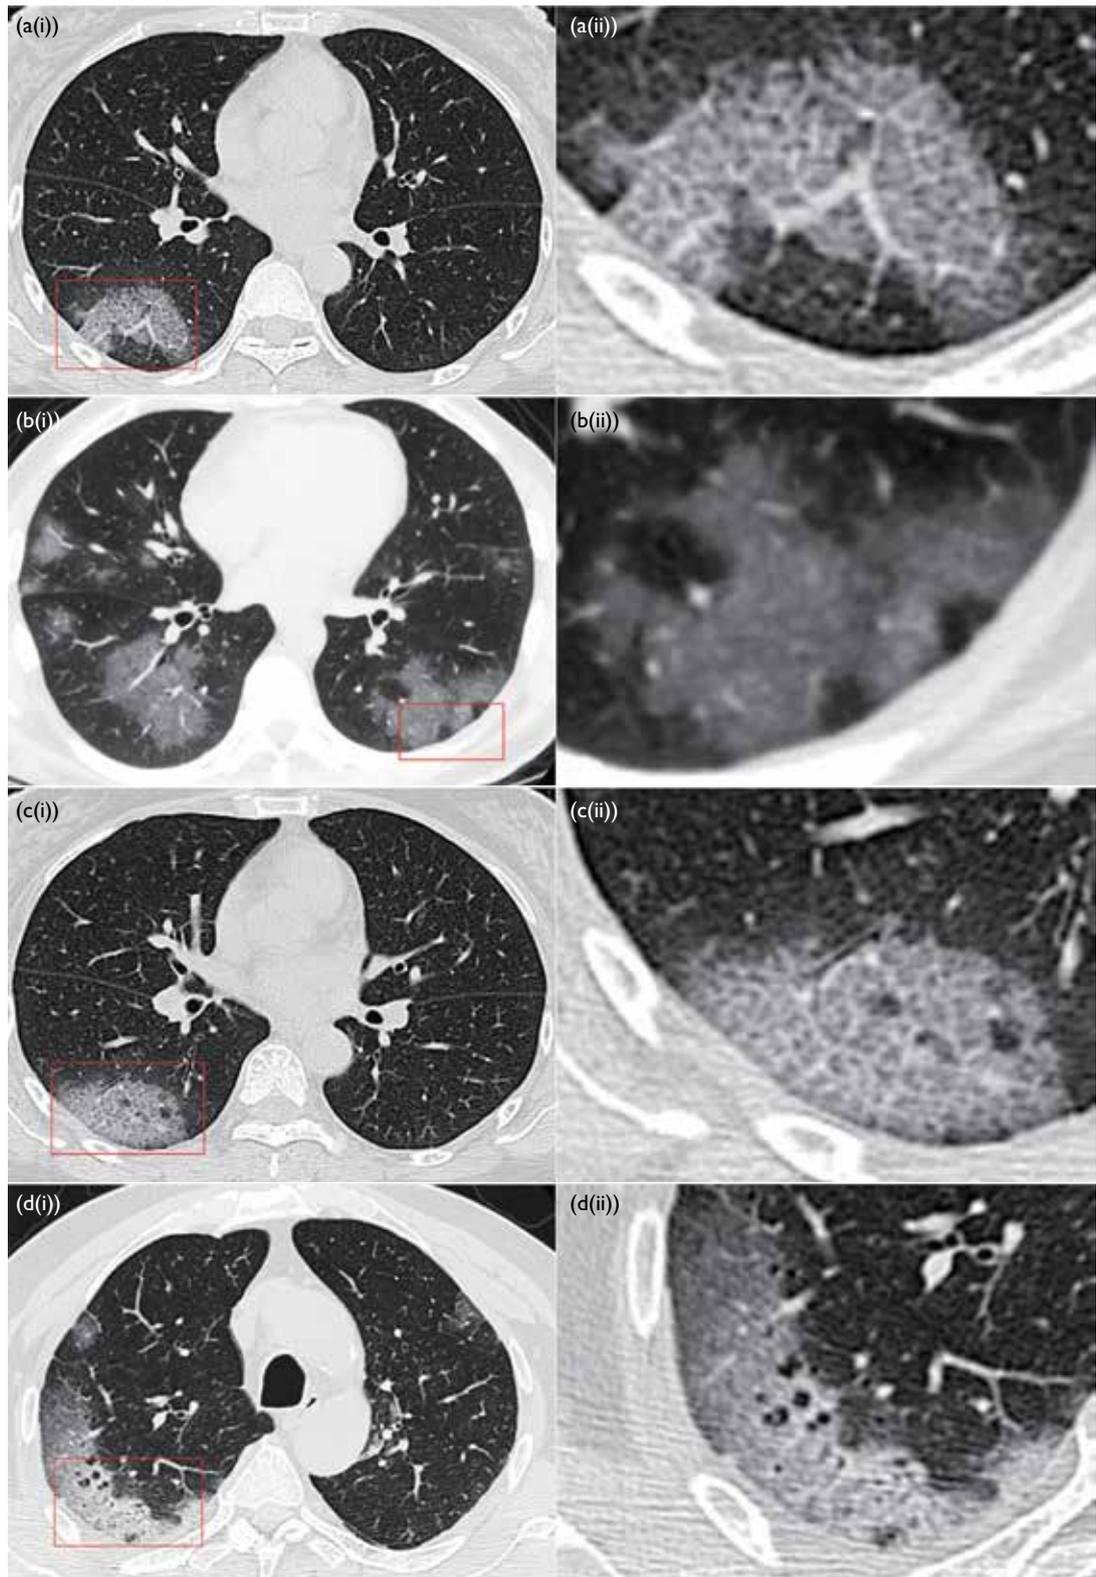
(a) The arched bridge sign. Axial computed tomography (CT) image (i) and magnified view of boxed area (ii) in a 56-year-old woman with coronavirus disease 2019 (COVID-19) pneumonia showing an arched ground-glass opacity (GGO) with a sharp underside outlining a semicircular region of spared lung. The typical subpleural location for the sign is evident. (b) Axial CT image (i) and magnified view of boxed area (ii) in a 35-year-old man with COVID-19 pneumonia showing a subpleural GGO with a sharp arched margin outlining two adjacent regions of spared lung, demonstrating a double arched bridge appearance. Other GGOs are also evident involving both central and peripheral lung parenchyma. (c) Vacuole sign. Axial CT image (i) and magnified view of boxed area (ii) in a 55-year-old woman with COVID-19 pneumonia showing a subpleural GGO with a few very small vacuole-like regions of sparing in the affected region. (d) Axial CT image (i) and magnified view of boxed area (ii) in a 56-year-old man with COVID-19 pneumonia showing a subpleural GGO with multiple very small vacuoles
